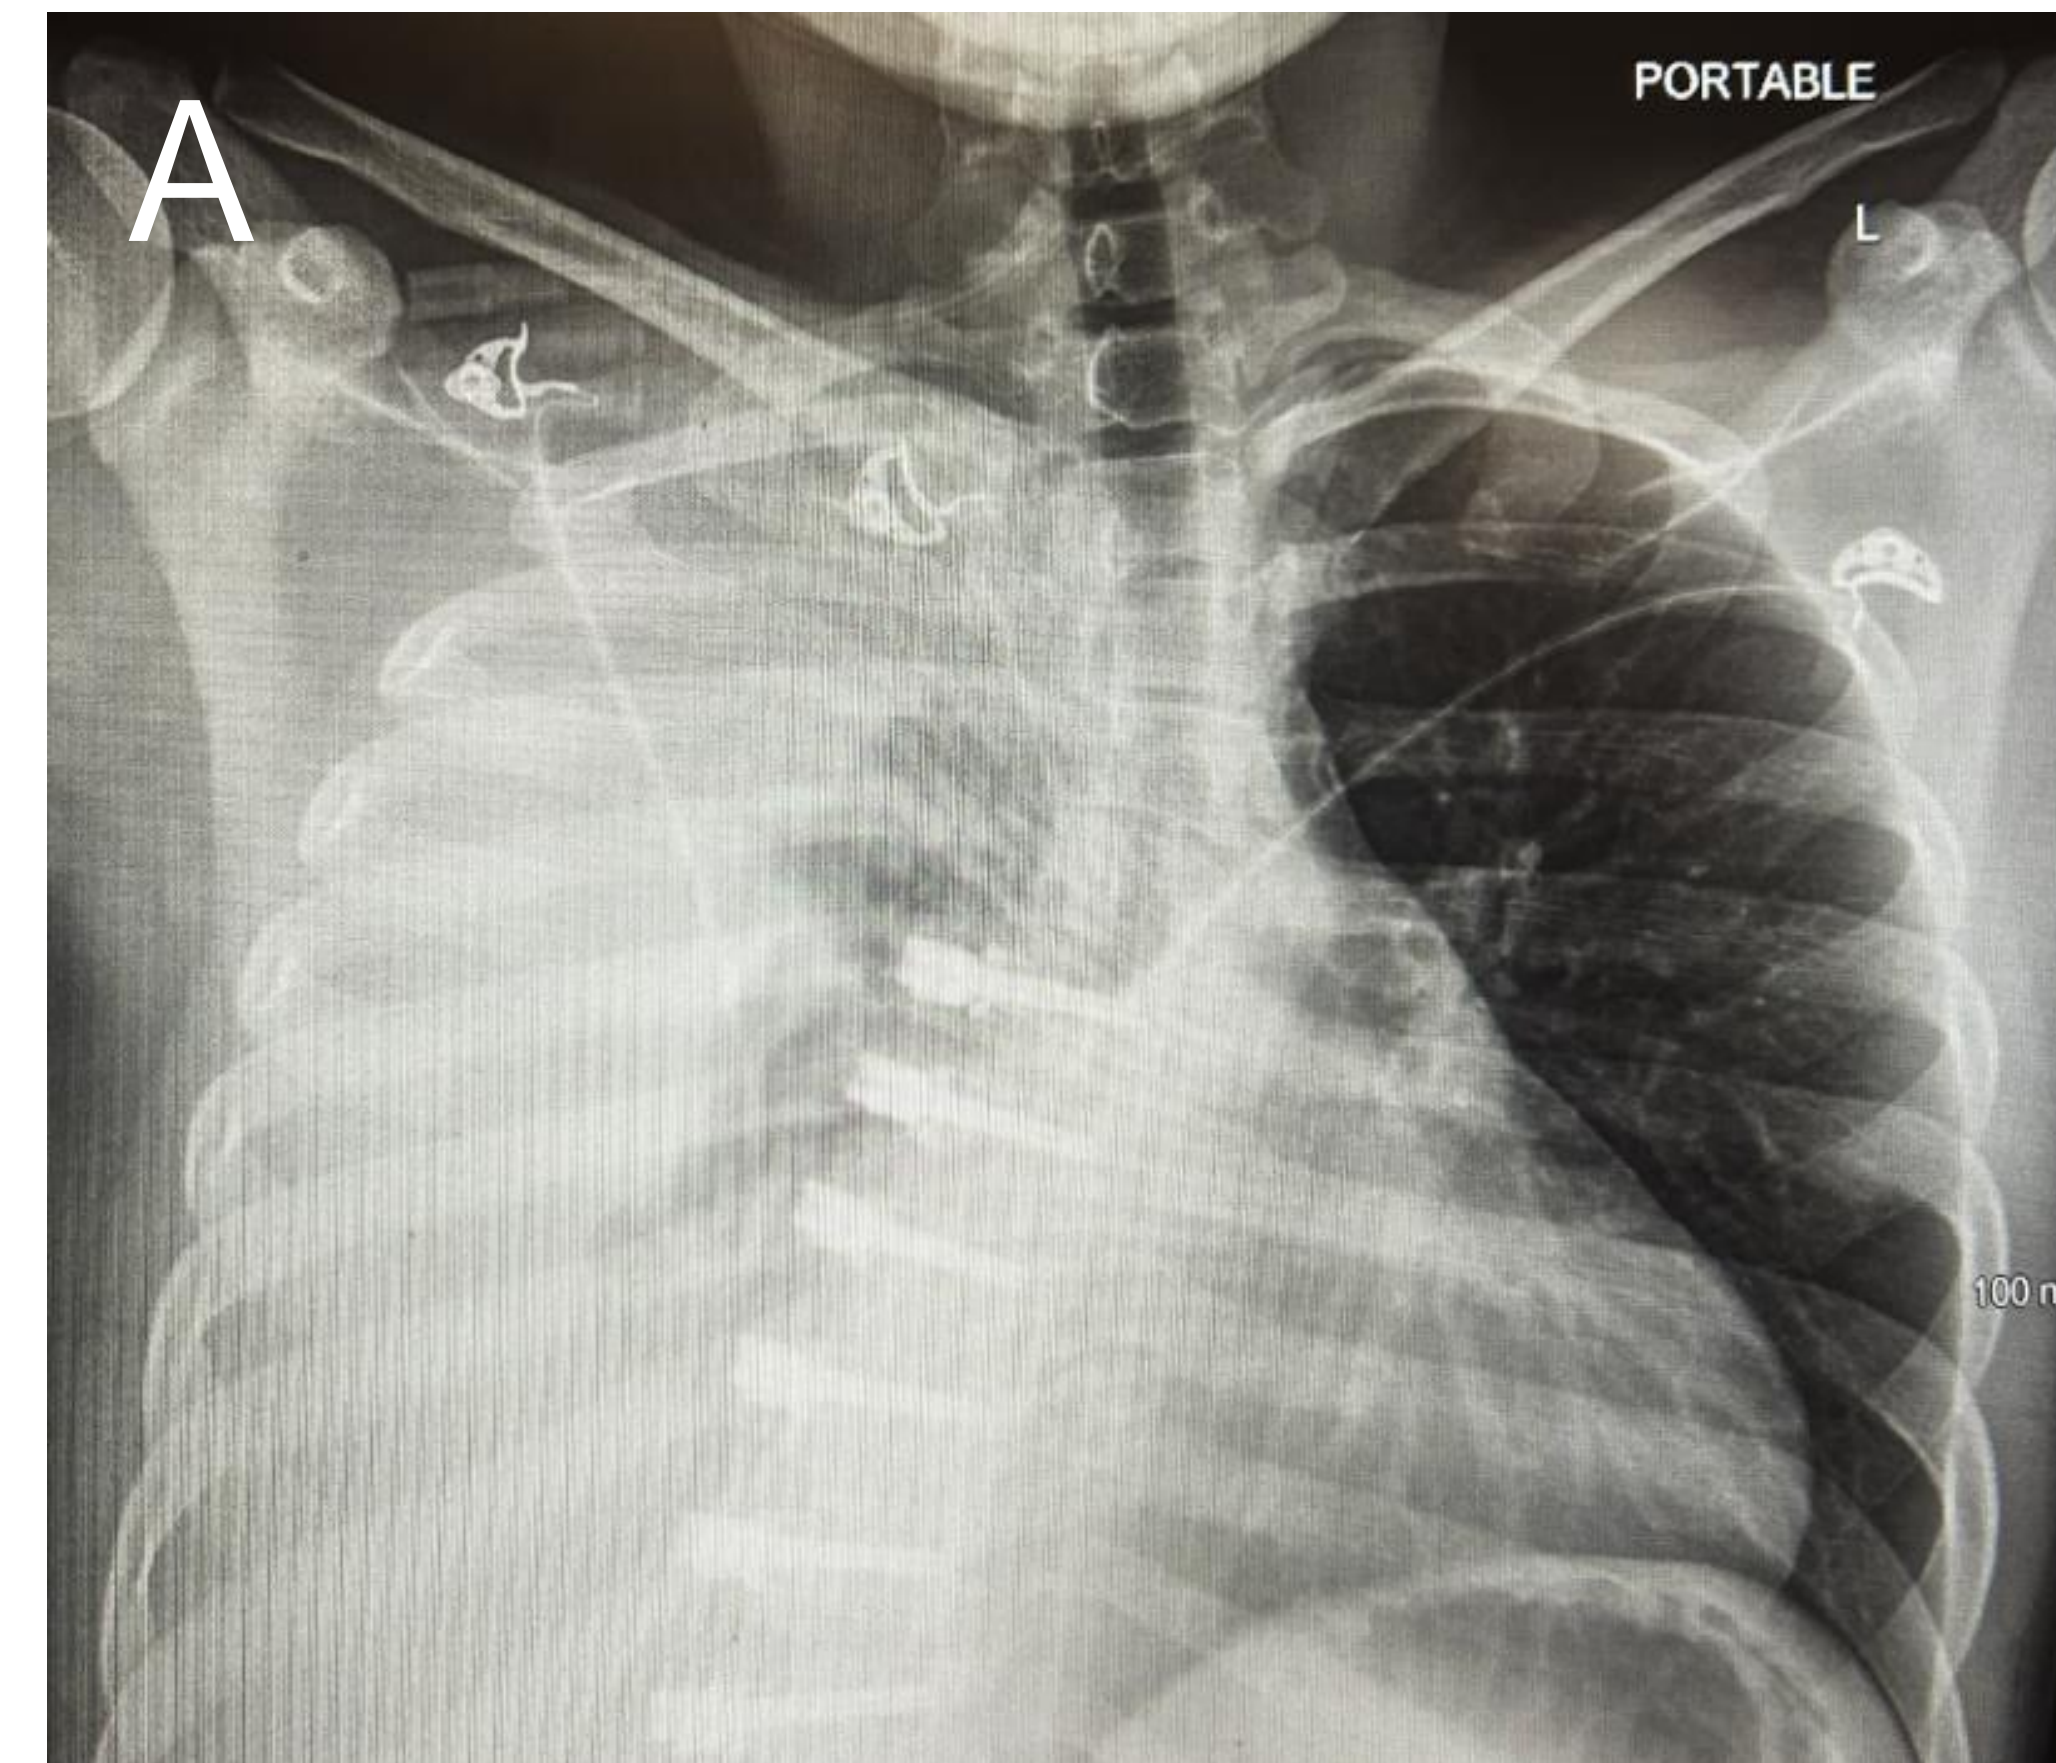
Figure A & B: Chest CT scans highlighting a significant hemothorax in the right hemithorax. Figure C: Chest X-ray, further confirming the presence of a hemothorax in the right hemithorax.
